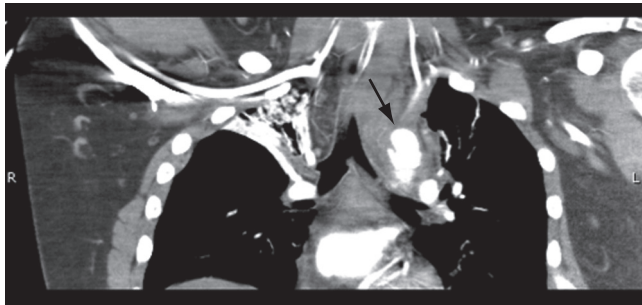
Chest computed tomography (CT) scan showing aortic intimal tear with surrounding mediastinal hematoma (arrow).
